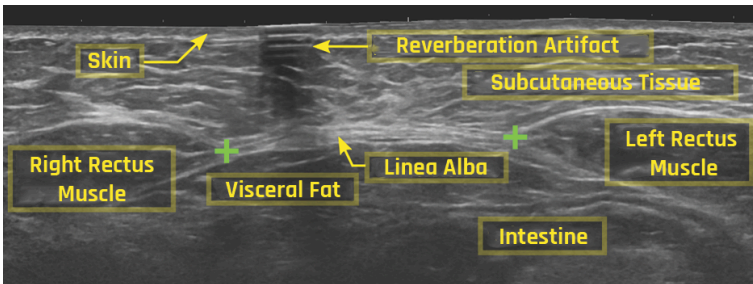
Reverberation artifacts are characterized as multiple horizontal lines that are equidistant from one another, and they are more pronounced as the intensity decreases with the depth. [Ultrasound of diastasis recti – annotated](#) by Mikael Haggström, M.D. licensed under [CC0 1.0](#)
